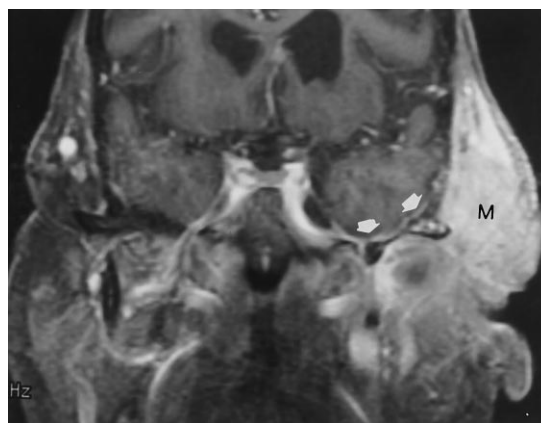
Contrast-enhanced, fat-suppressed, T1-weighted (600/11/1) MR image. Note the linear enhancement (arrows) of the dura along the inferior temporal lobe in this patient who had a squamous cell carcinoma (*M*) invading the masticator space and subcutaneous tissue. No dural infiltration was noted at pathologic examination.
